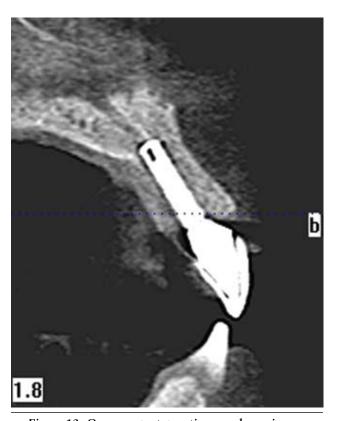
One-year postoperative cone beam image.
